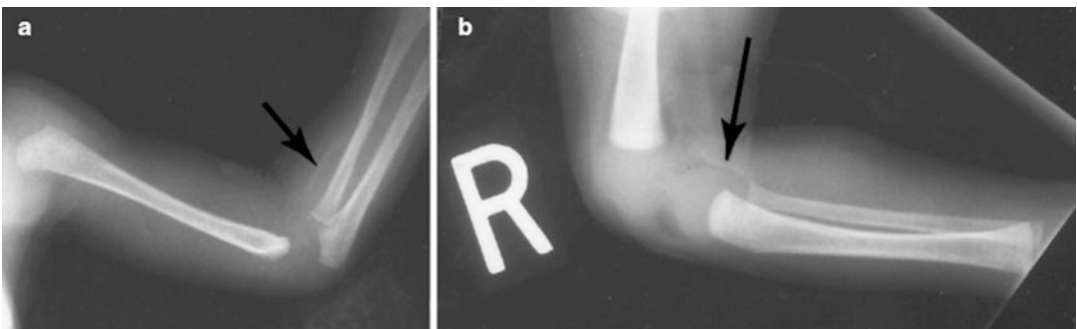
(a,b) Radiographs of twin B show linear calcification (*arrow*) of the radial artery (*upper*) and popliteal artery (*lower*). At 35 days of age, the twin suffered a cardiac arrest and expired shortly thereafter. No autopsy was performed
